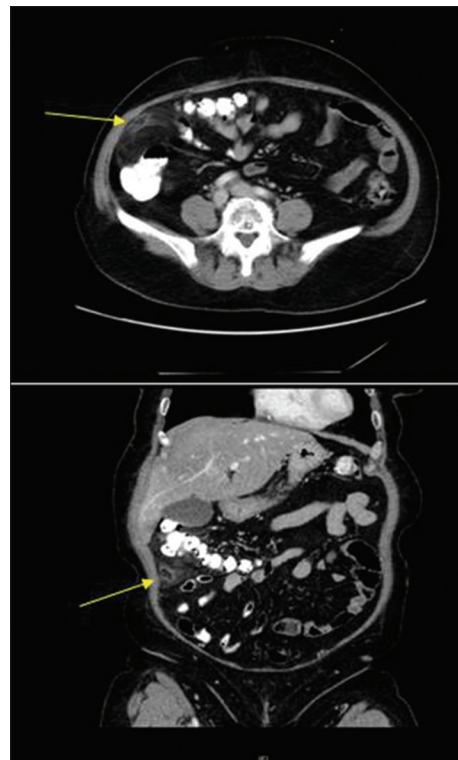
Initial computed tomography scan. Right lower quadrant fat-stranding consistent with small omental infarction in location of patient's pain as indicated by the pointing arrow
